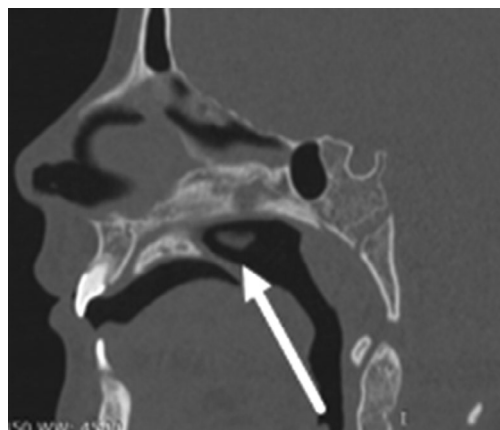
Anterior displacement of the posterior nasal spine, short vomer and posterior ends of the inferior nasal turbinates protruding into the lumen of the nasopharynx (arrow) in the sagittal view in an X-ray computed tomography image.
